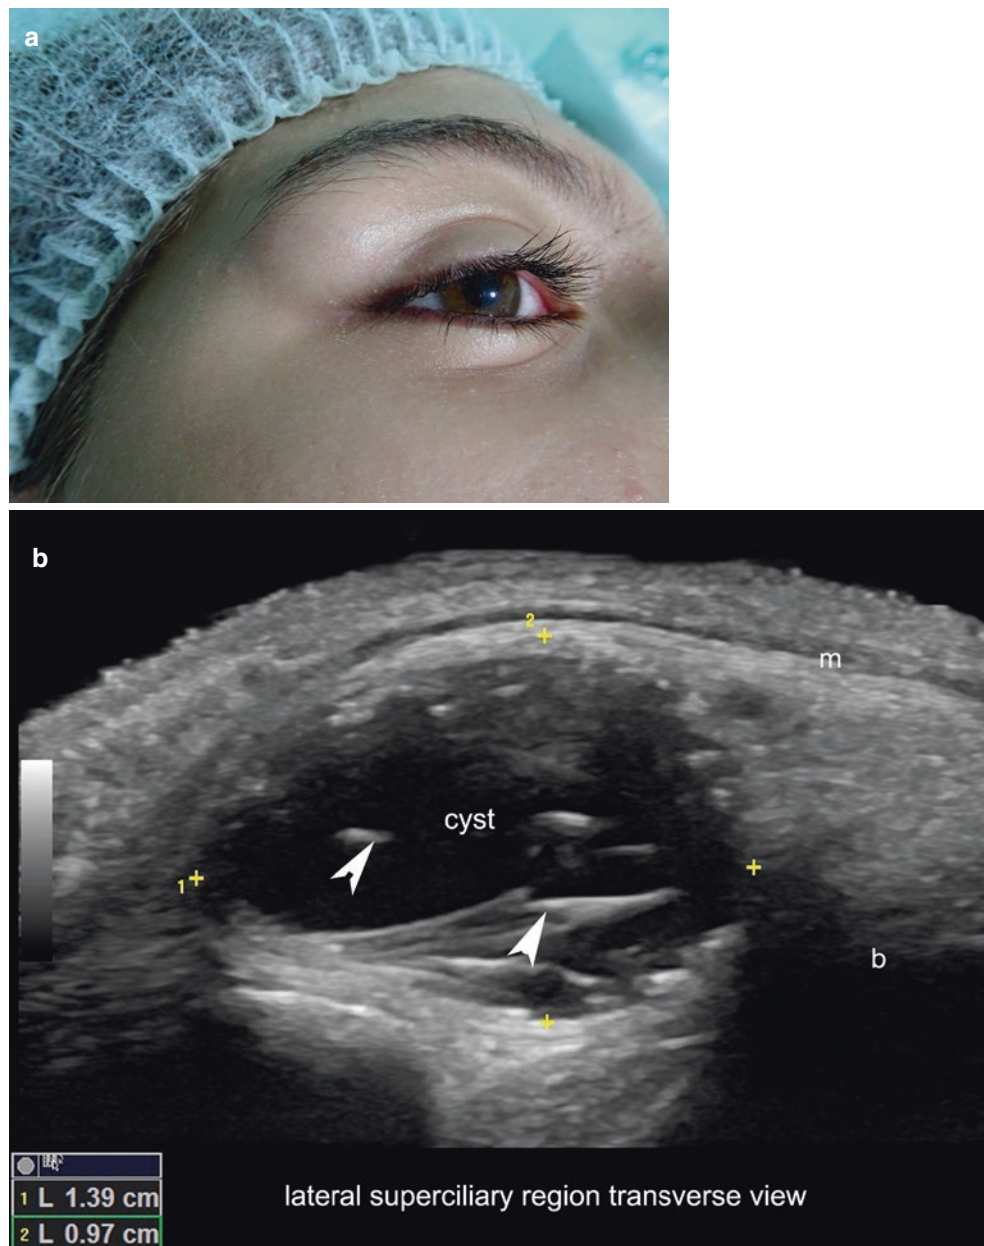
Dermoid cyst. (a) Clinical image. (b) Ultrasound (greyscale, transverse view, right superciliary region) demonstrates 13.9-mm (transverse) × 9.7-mm (thickness), well-defined, oval-shaped, anechoic cystic structure beneath the lateral part of the upper orbicularis muscle of the eyelid (m) which is displaced superficially. Notice the hyperechoic linear structures, which correspond to hair tracts (*arrowheads*). (c) Color Doppler presents slightly increased vascularity in the periphery; however, there is no vascularity within the cyst. *b* bony margin. See Video 3.6.
